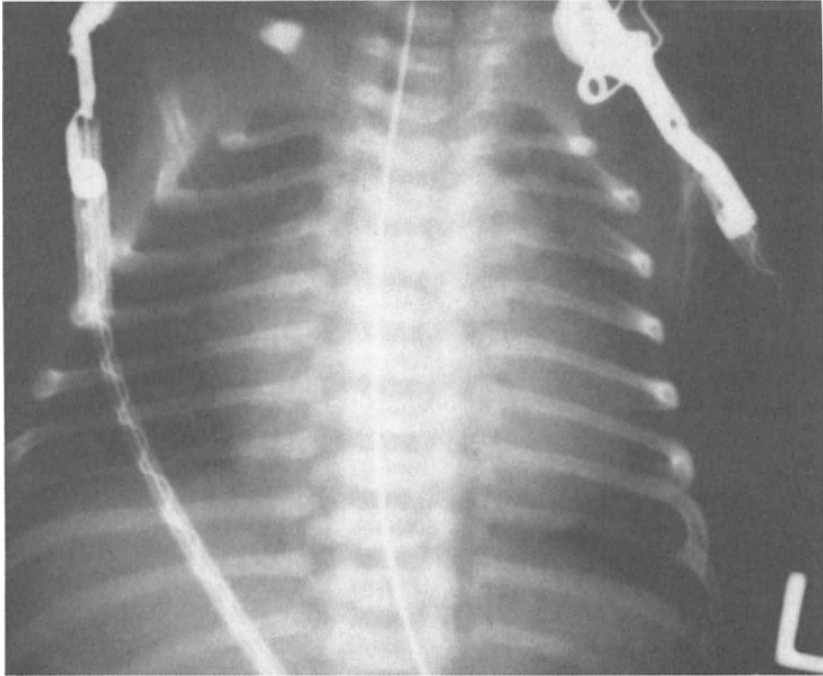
Chest roentgenogram of a newborn with hypoplastic left heart syndrome showing cardiomegaly and increased pulmonary vascular markings.
